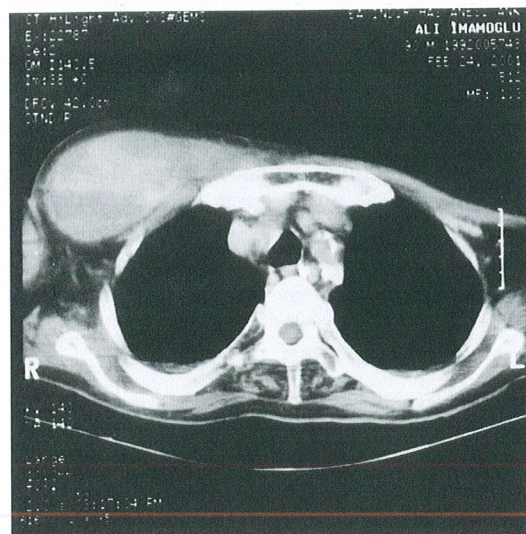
Pectoral Muscle Hematoma was seen in thoracic computed tomography.
